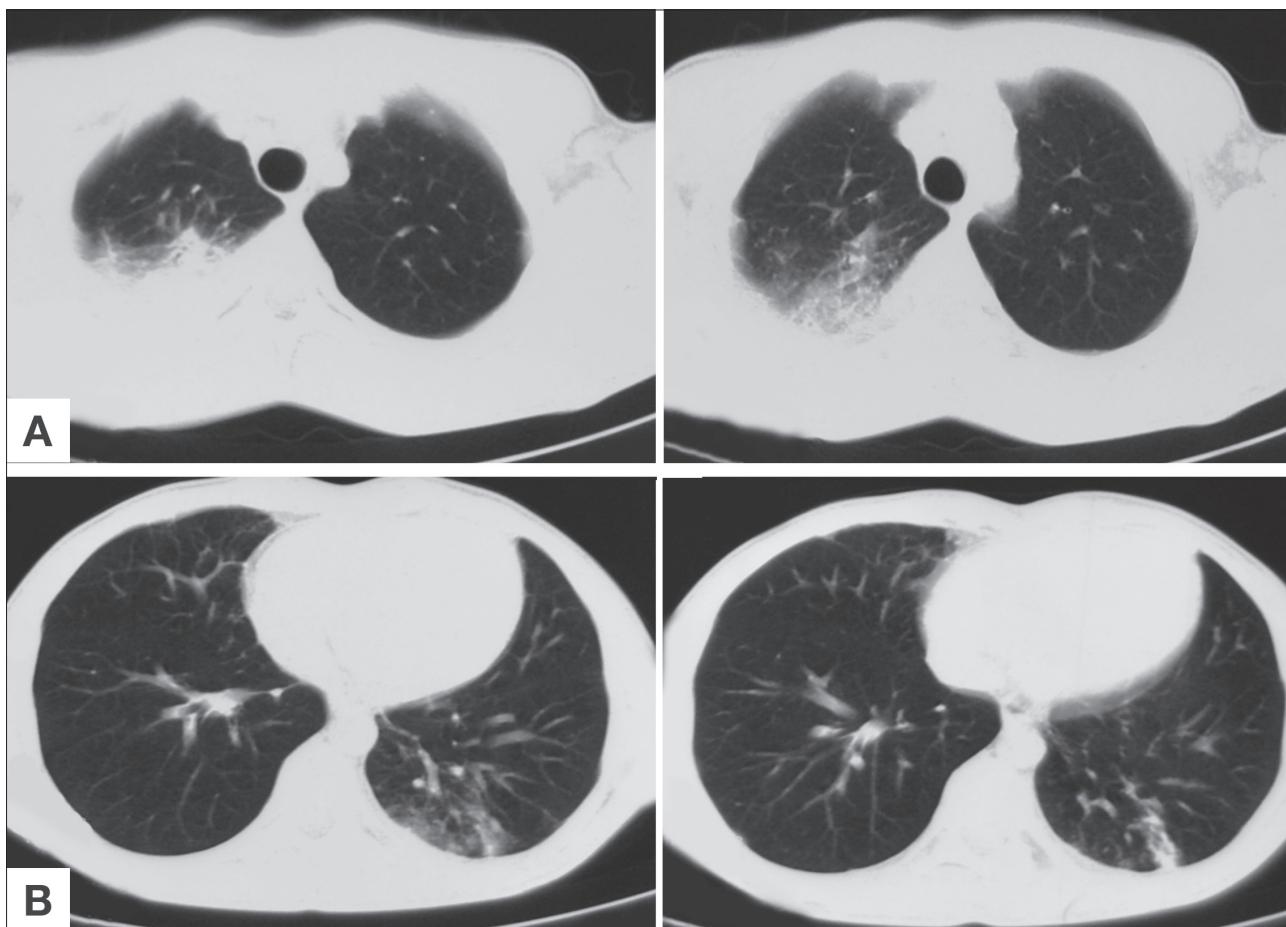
(Case 2) (A) Presenting thoracic CT, (B) presenting thoracic CT.
